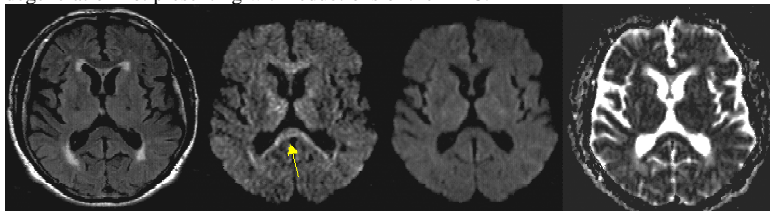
FLAIR images (a) of an 80-year old male with Grade 2 WML lesions. Single diffusion direction DWI (b), DWI trace image (c) and ADC map (d) show no signal abnormalities. Yellow arrow shows anisotropy artifact of the corpus callosum, not visible on trace image.
